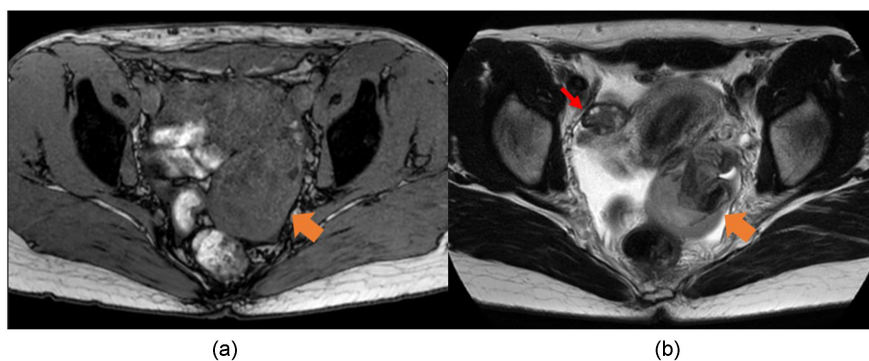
Magnetic resonance image of the left adnexal region (→) and right ovary (→). (a) T1-weighted images show a heterogeneous mass with low to equal signaling. (b) T2-weighted images show a mixed mass with low and high signals suggestive of a hematoma.
